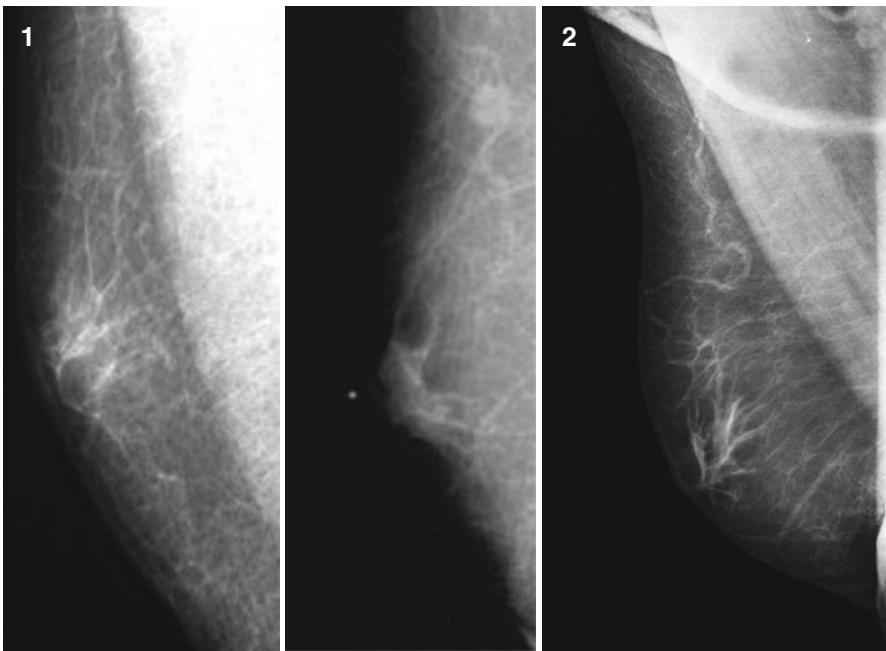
(1, 2) X-ray mammograms. Healthy male breast
